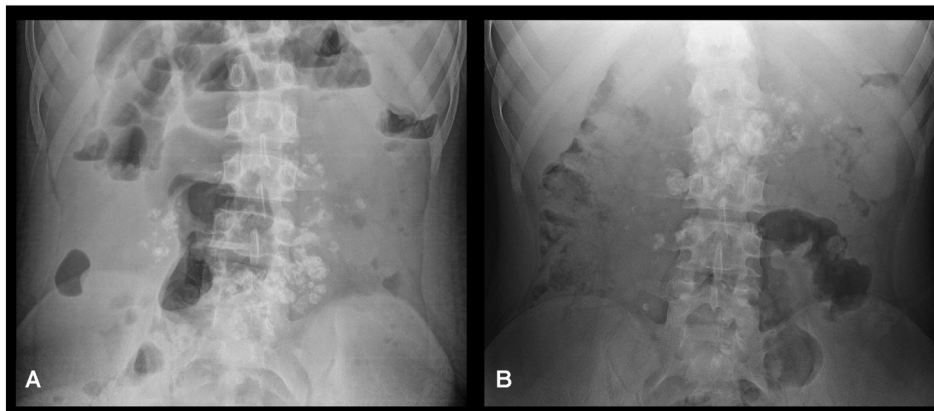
(A) Plain abdomen X-ray showing multiple calcified mesenteric lymph nodes. (B) 34 month follow-up plain film showing fewer and less dense calcified mesenteric lymph nodes.
